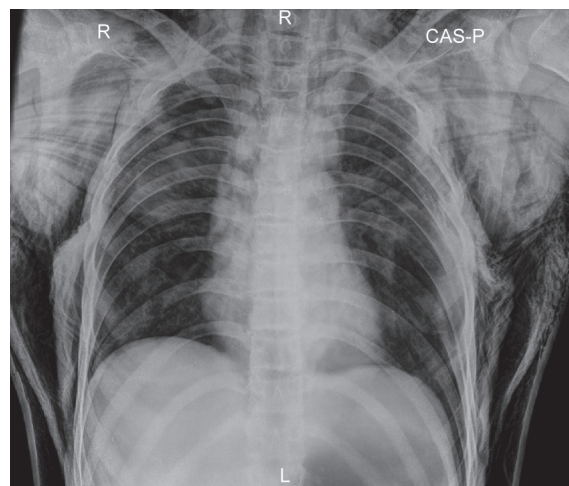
Chest X-ray before insertion of intercostal drains
